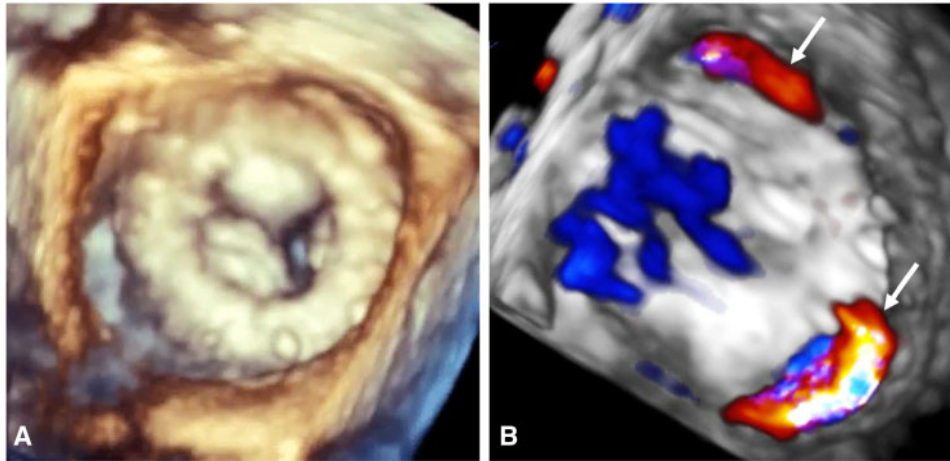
Baseline echocardiographic assessment. (A) Pre-procedural transoesophageal echocardiography 3D atrial view from the surgical mitral bioprosthesis showing severe stenosis. (B) 3D Doppler atrial view showing the localization of the paravalvular leaks. White arrows indicate the location of paravalvular leak.
